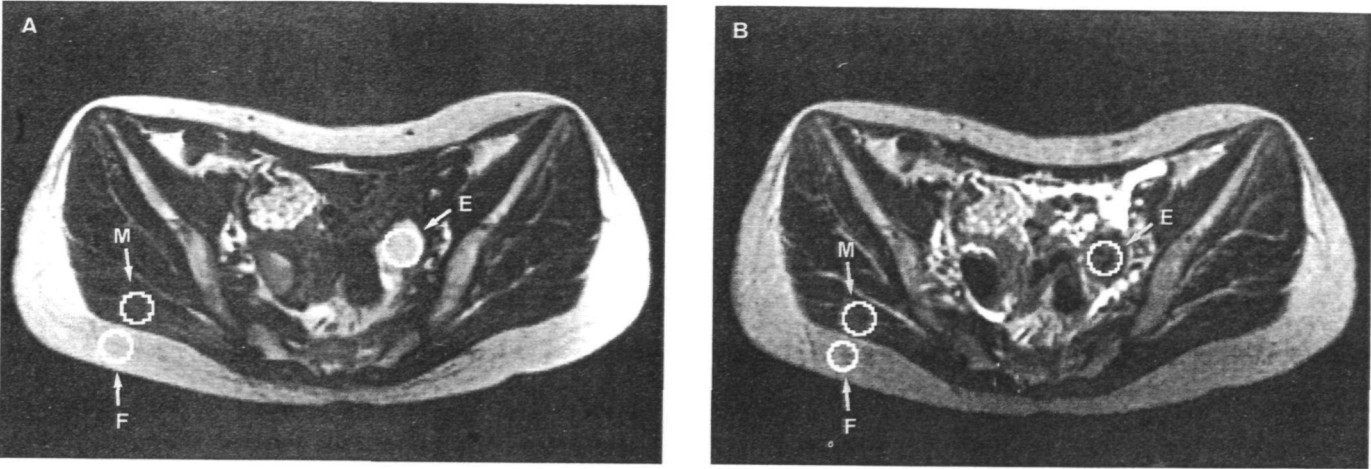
Magnetic resonance image of the left endometrial cyst. (A) T_1 -weighted image [spin-echo sequence, repetition time (T_R) 600 ms, echo time (T_E) 15 ms] and operator-defined regions of interest (E = endometrial cyst; M = muscle; F = fat) are shown. (B) T_2 -weighted image (spin-echo sequence, T_R 2200 ms, T_E 80 ms) and operator-defined regions of interest (E, M and F) are shown. The endometrial cyst demonstrates a high signal intensity on the T_1 -weighted image and a low signal intensity on the T_2 -weighted image.
